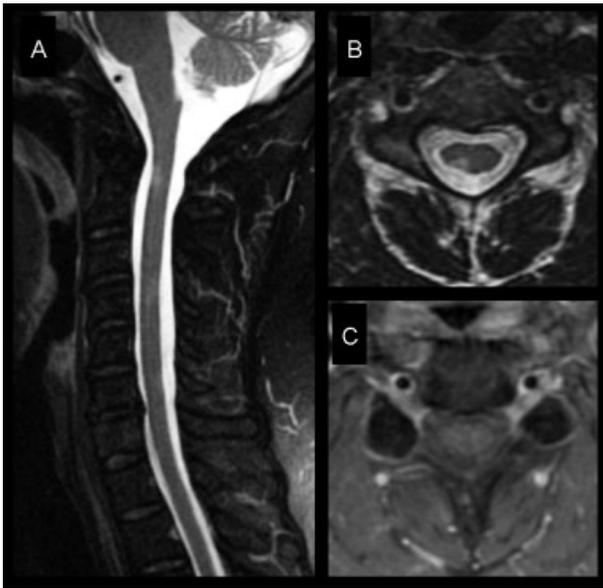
Multiple sclerosis. Sagittal (A) and axial (B) T2-weighted magnetic resonance images in a patient with clinically definite multiple sclerosis, without enhancement on gadolinium-enhanced T1-weighted images (C). Note the sharply marginated, short-segment plaque that is peripherally located within the cord axis and predominantly located within the white matter of the cervical spinal cord. The patient also had multiple plaques in the periventricular white matter (not shown).
